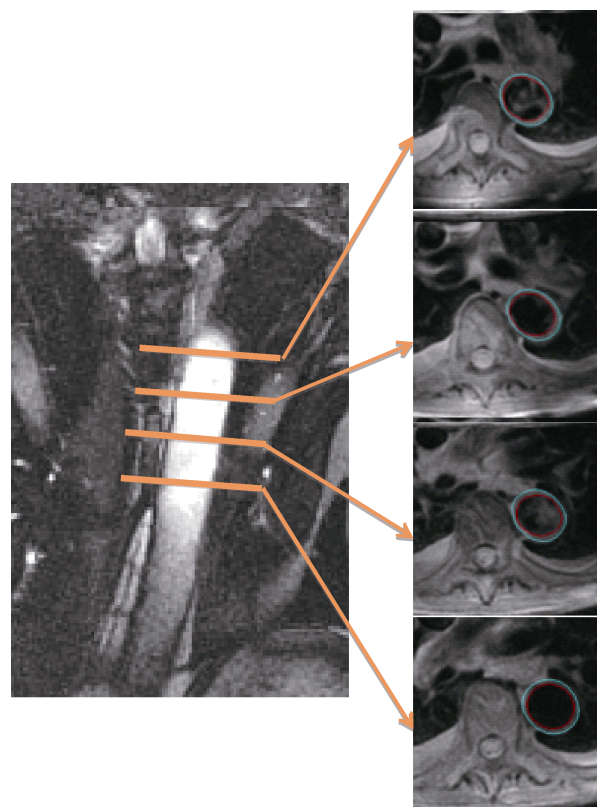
Aortic atherosclerosis imaging and analysis by magnetic resonance imaging. The aortic images were obtained using a cardiac gated triple inversion black blood imaging sequence with flow and fat suppressions as shown on the left. The first of 4 consecutive cross-sectional images with 8 mm thickness and 2 mm gap was positioned immediately after the aortic arch. Total aortic wall coverage was 40 mm. On the right, images show that cross-sectional aortic wall area was quantified by placing contours around lumen and outer-wall boundaries of the aorta and subtracting lumen area from outer-wall area.
